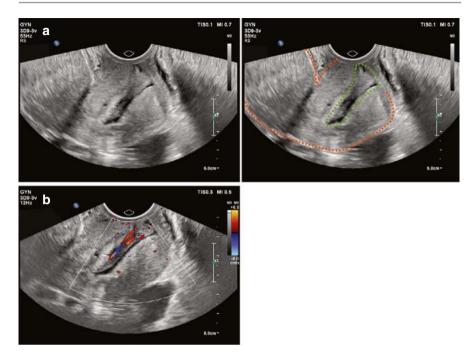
(a) B-mode ultrasound shows a large cervical polyp protruding through the external cervical os, surrounded by a fluid-filled area (cervical canal effusion). The uterus and cervix are circled in orange; the cervical polyps is circled in green. (b) Blood flow within the polyp is demonstrated using color Doppler ultrasound
